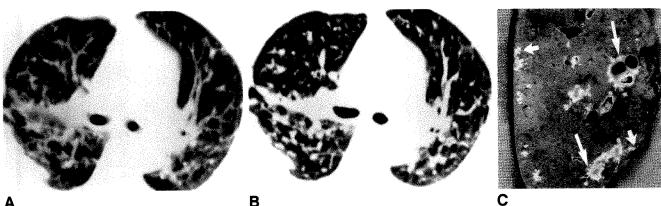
55-year-old woman with 5-year history of sarcoidosis developed a neoplastic lesion in right upper lobe and underwent right upper lobectomy. A, 10-mm collimation CT scan shows irregular nodules mostly along bronchovascular bundles (arrows) and in subpleural region. Process is most severe in right lower lobe, where a large pleura-based abnormality presumably is a conglomeration of subpleural granulomas. Only a few peribronchovascular nodules are present in right upper lobe.
